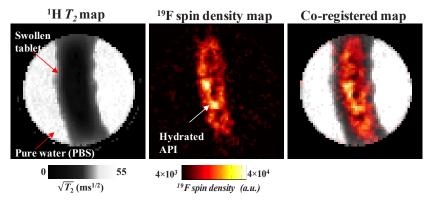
Co-registration of quantitative ¹H T₂ images and ¹⁹F spin density MR images from the model tablet (70% HPMC K4M, 30% TFDH, w/w) after 9 hr upon dissolution.
